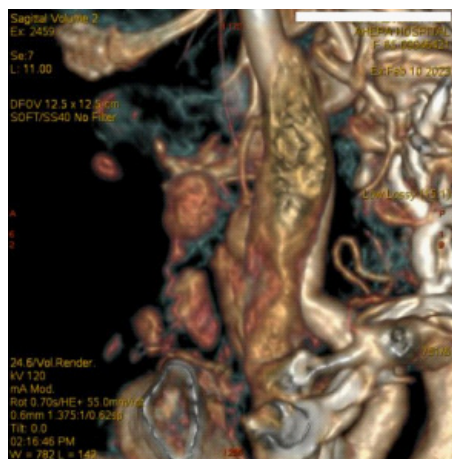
4D-CT depicting multiple parathyroid foci along the left sternocleidomastoid muscle.
